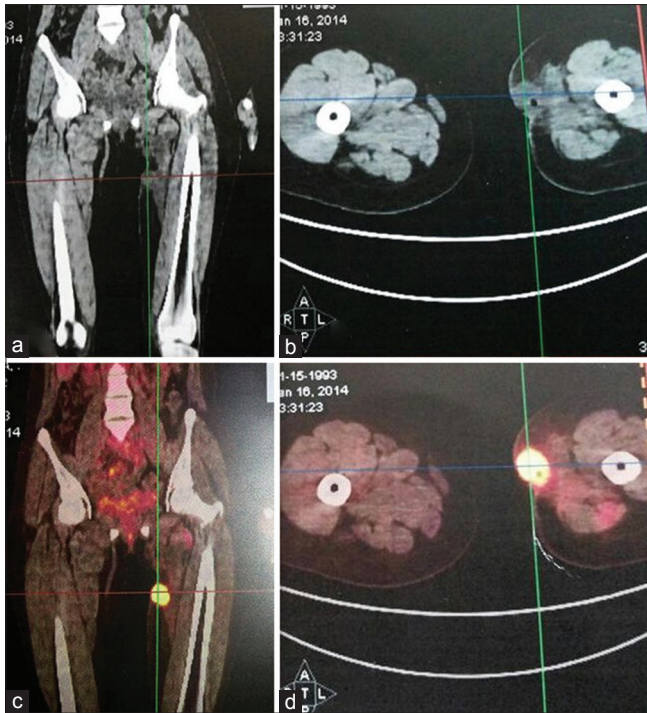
Computed tomography scan showing soft tissue mass (a and b) while positron emission tomography scan revealing a metabolically active lesion at medial side of left thigh (c and d)
